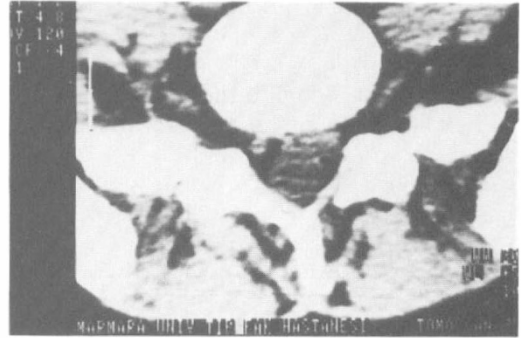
CT scan of the same case revealed obvious soft tissue density on the left side where we can detect the right S1 root within the epidural fat tissue.
